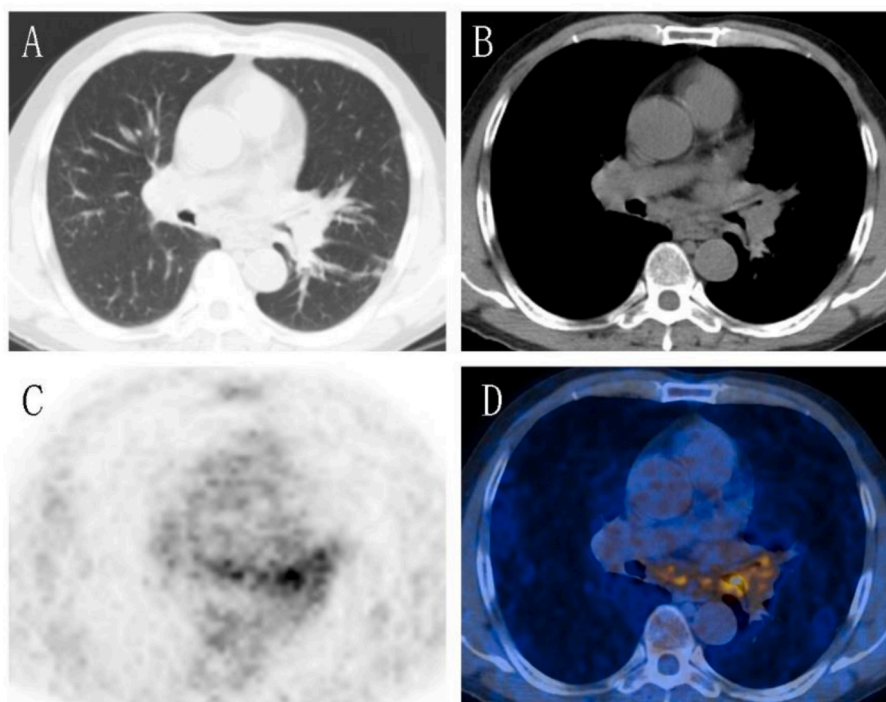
^{18}F -FDG PET/CT was performed. Transverse CT(A,B),corresponding PET(C), and fusion(D) image showed intense FDG uptake of multiple nodules.
